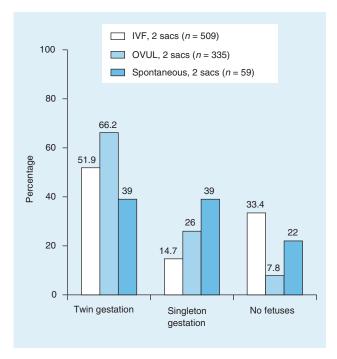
Outcome beyond the first trimester in assisted versus spontaneous conceptions after the early sonographic diagnosis of two sacs (n = 903). Comparison of *in vitro* fertilization (IVF), ovulation induction (OVUL) and spontaneous conceptions^{8,9,11,12}
